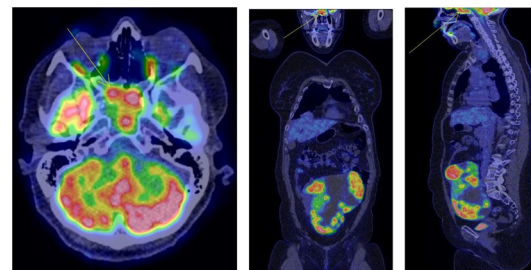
Positron emission tomography-CT scan (axial, coronal and sagittal) showing positive fluorodeoxyglucose uptake in the sphenoidal sinus.
